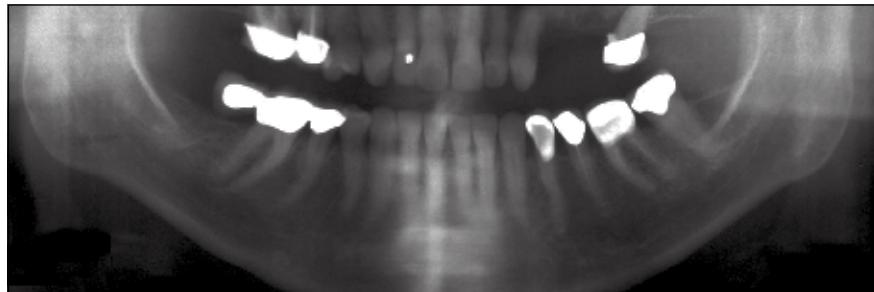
2004 panoramic radiograph. Note the normal trabecular pattern.
